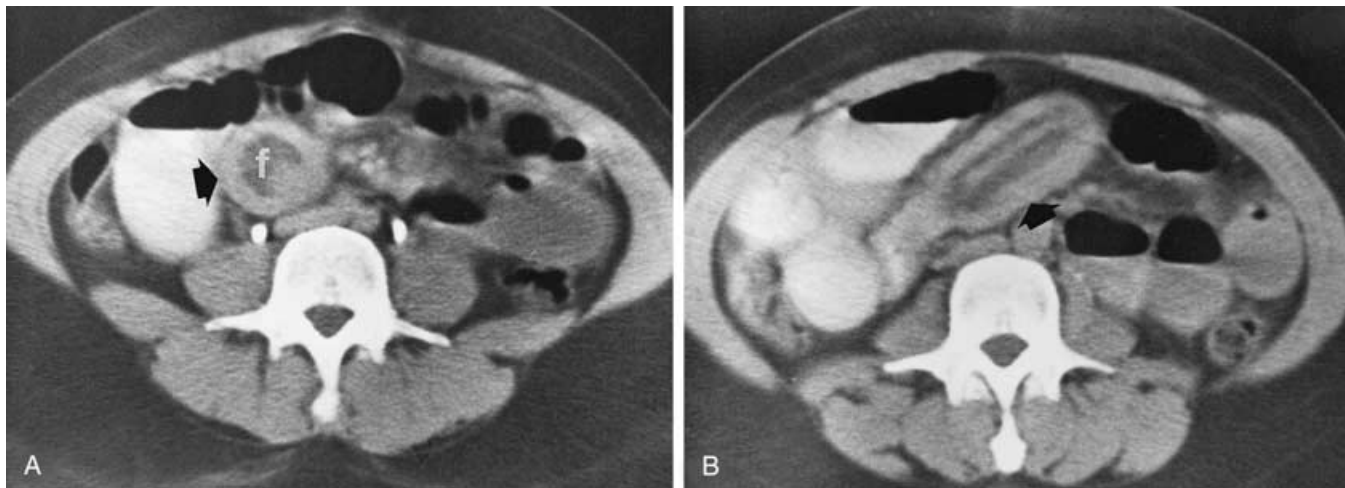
Acute small bowel intussusception. The patient had a sudden onset of severe mid-abdominal pain with nonspecific plain film findings. Cross-sectional (A) and longitudinal (B) CT scans showed a small bowel intussusception (*arrows*). Mesenteric fat (f) accompanies the intussusceptum. A benign spindle cell tumor was the cause.
